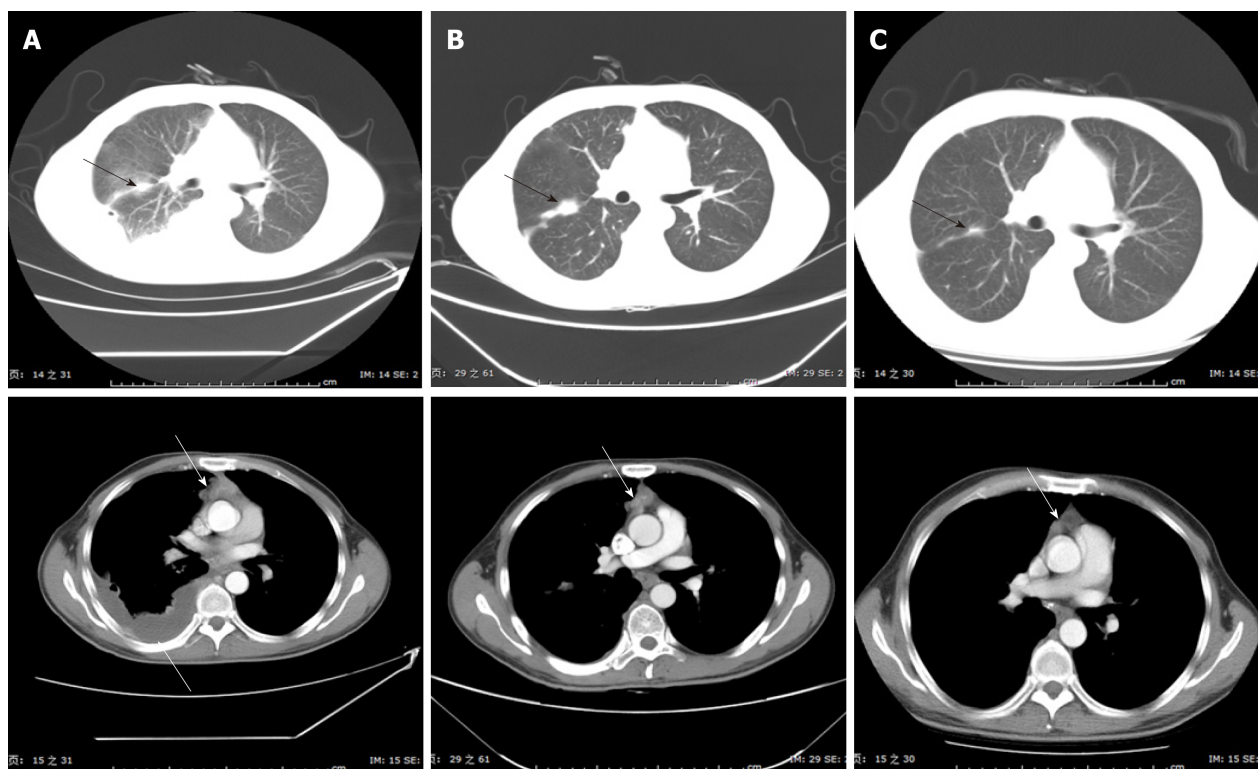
Images from computed tomography showing the tumor in the right lung and mediastinum in response to therapy. A: Before therapy, imaging performed on May 2, 2013; B: After two cycles of DP therapy, imaging performed on June 7, 2013 and evaluation classified the status as a progressive disease; C: After six cycles of TP therapy, imaging showed that the tumor had shrank significantly. DP: 75 mg/m² docetaxel on day 1 and 75 mg/m² cisplatin on day 1; TP: 100 mg/m² nab-paclitaxel (nab-PC) on days 1, 8, and 15, and 75 mg/m² cisplatin on day 1.
